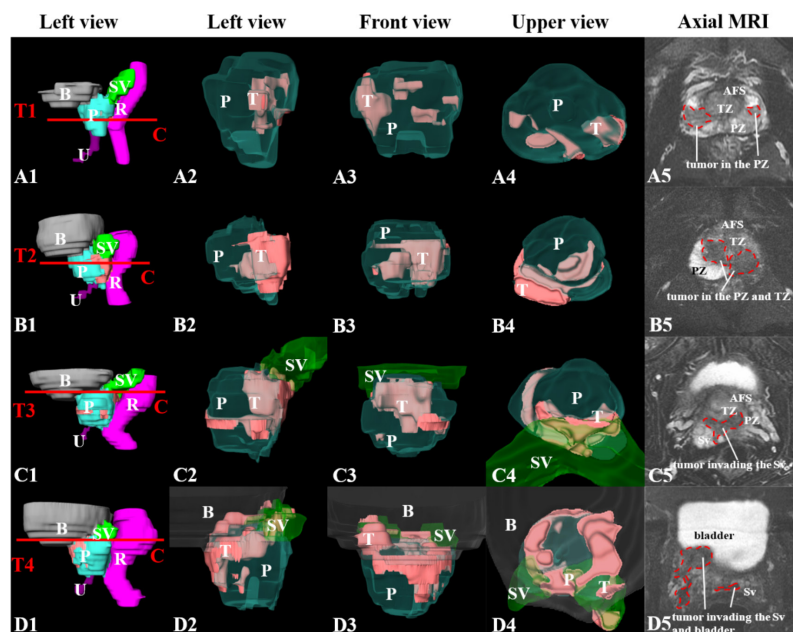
Three-dimensional reconstruction, spatial relationship, and location of prostate cancer lesions in different T-stages. Column A1–D1, three-dimensional reconstruction of the prostate and adjacent structures in the left view. Column A2–D2, A3–D3, and A4–D4, three-dimensional reconstruction of the tumor and prostate in the left, front, and upper views, in which the prostate, seminal vesicles, and bladder are semi-transparent. Column A5–D5, tumor segmentation in axial magnetic resonance images. Row A1–A5, T1 PCa; row B1–B5, T2 PCa; row C1–C5, T3 PCa; row D1–D5, T4 PCa. PCa, prostate cancer; PZ, peripheral zone; TZ, transition zone; CZ, central zone; AFS, anterior fibromuscular stroma; B, bladder; SV, seminal vesicles; R, rectum; U, urethral canal; P, prostate; T-stages, tumor-stages.
